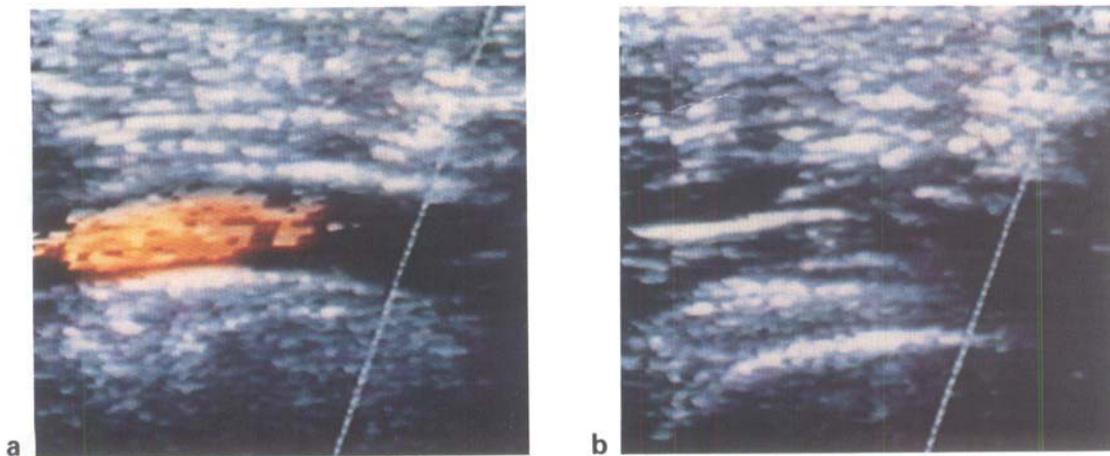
a Colour Doppler ultrasonographic image of an apparently normal popliteal artery at rest with blood flowing through it. b When entrapment is unmasked by resisted plantar flexion the lumen is occluded by extrinsic compression and blood flow ceases
